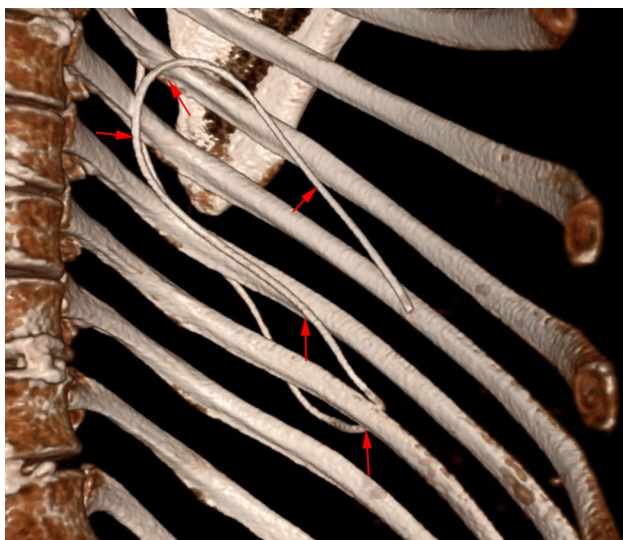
Three-dimensional CT images show the potential points of intercostal nerve irritation due to proximity, as marked by the red arrows.
